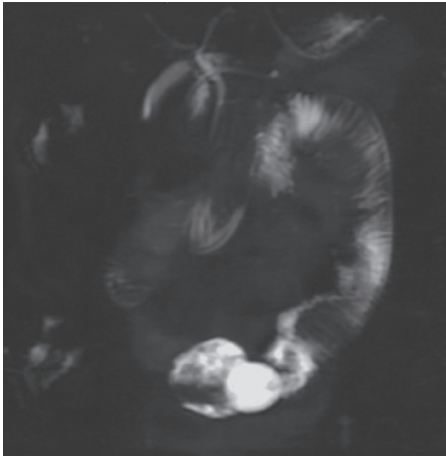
Abdominal MRI. Extension of the small intestine was improved.
